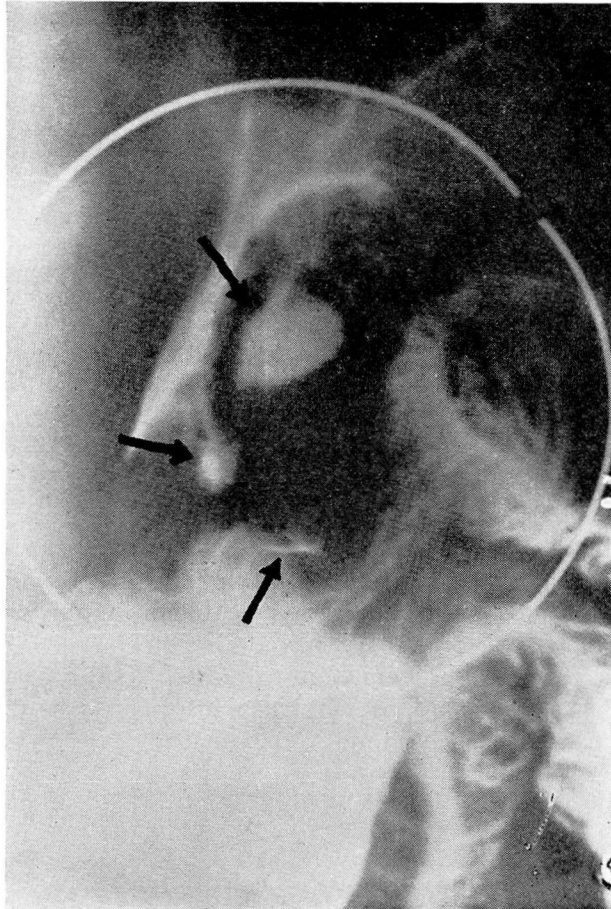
Fluoro-roentgenogram of a gastric neurofibroma. This film was made with moderate degree of compression to show the smooth contour of the tumor and the three ulcer niches.
